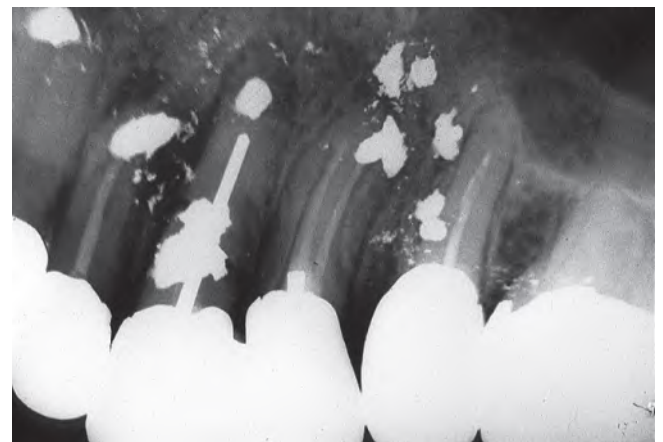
Indiscriminate use of periapical surgery in patients is unethical and is one of the contraindications of this procedure.
